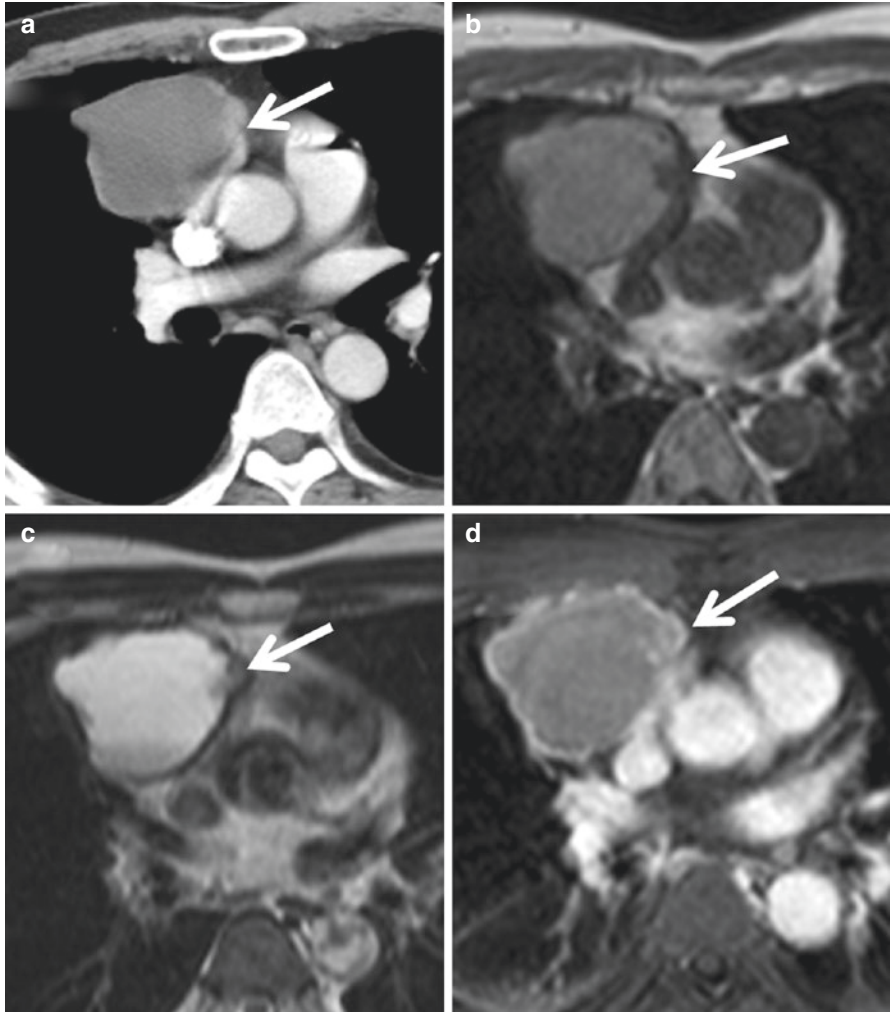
A 43-year-old man with cystic thymic carcinoma. (a) Enhanced CT shows a plaque-shaped mass measuring 6.2 cm in maximal diameter, at the level of the right pulmonary trunk in the right anterior mediastinum, with lobulated contour, which presents intratumoral cystic attenuation content (mean densitometric value, 15 HU) and irregular thickening enhanced tumor capsules (mean densitometric value, 61HU). (b) The cystic mass shows mild low signal intensity of the tumor capsule and mild high signal intensity of the cystic content compared to that of muscles on unenhanced T1-weighted MR imaging. (c) The cystic mass shows mild high signal intensity of the tumor capsule and strongly high signal intensity of the cystic content on T2-weighted MR imaging. (d) The cystic mass shows moderate enhancement of the irregular tumor capsule and nonenhancement of the cystic content on axial contrast-enhanced fat-suppressed T1-weighted MR imaging at the same level
